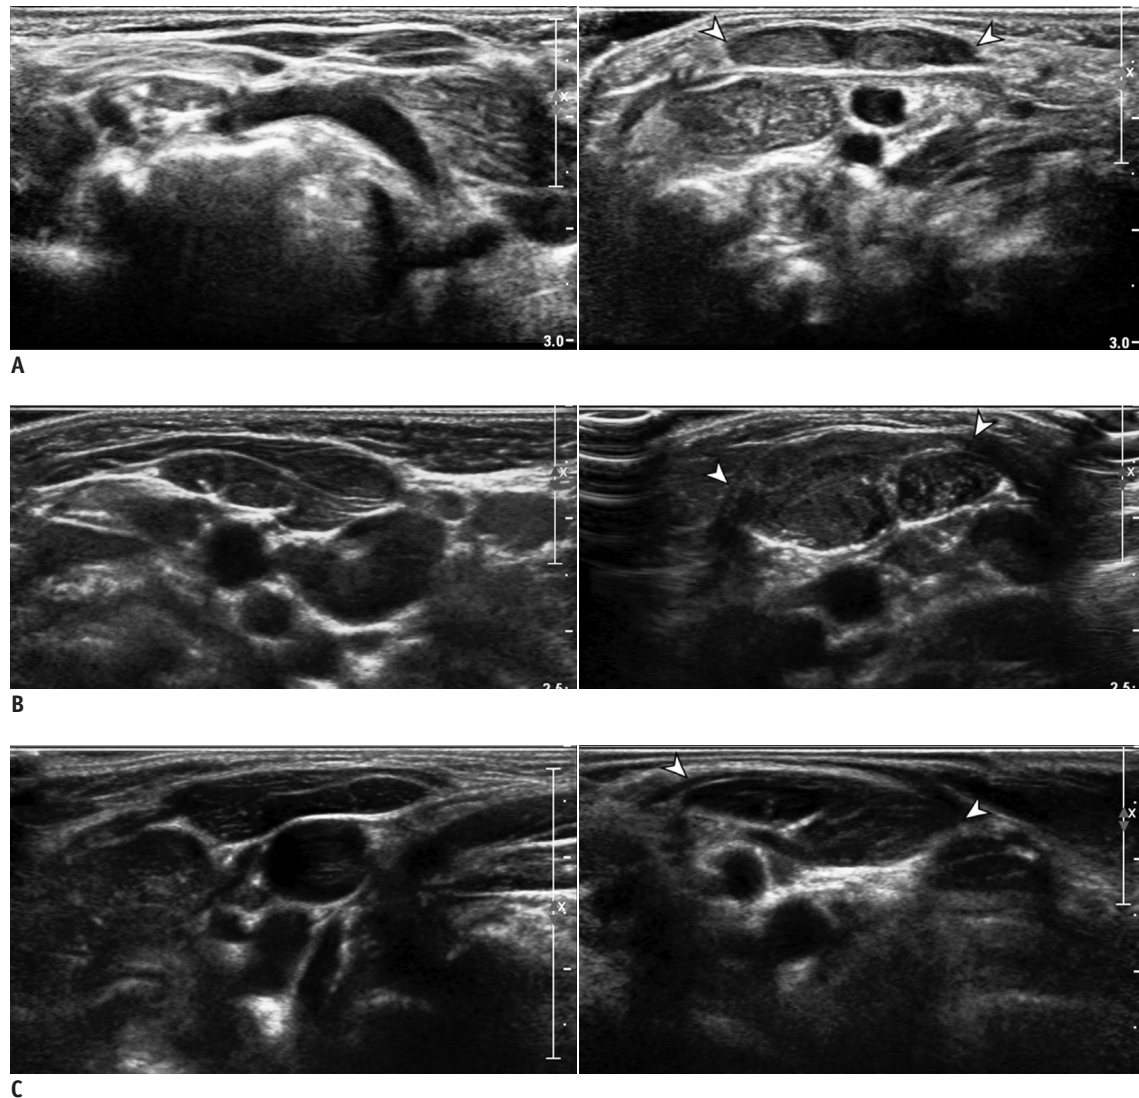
Transverse sonograms of non-affected (left panel) and affected (right panel) SCMs in three patients.
